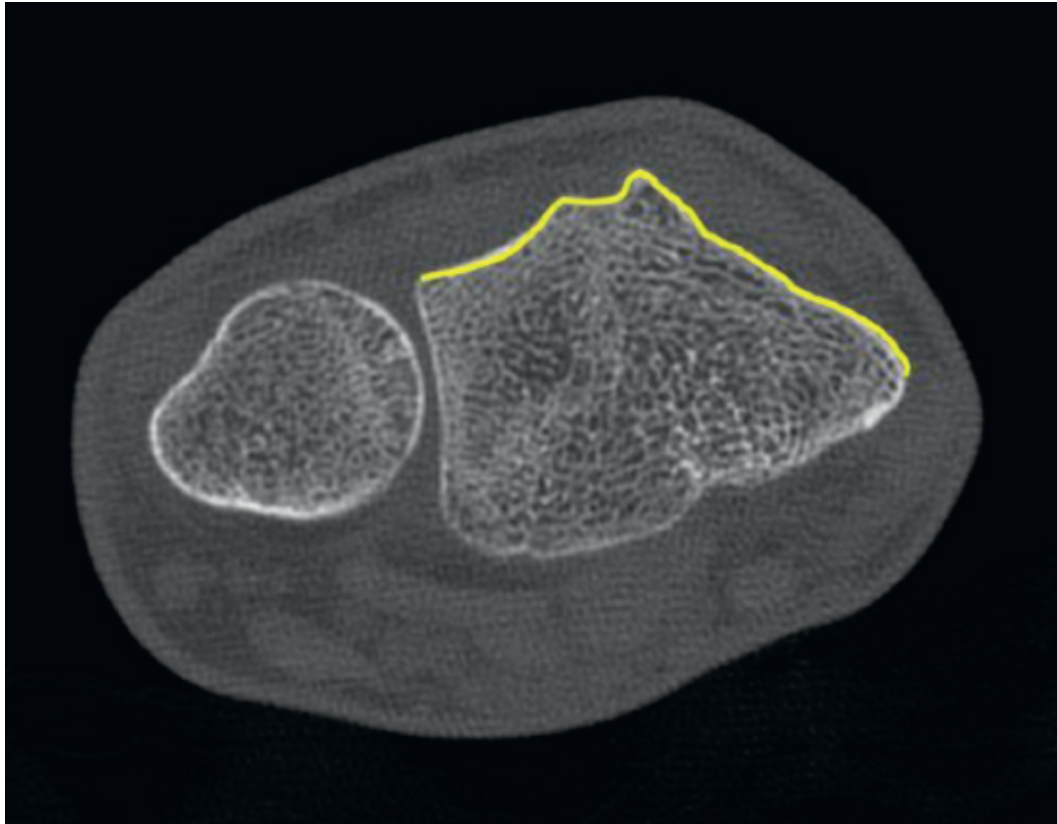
Axial CT image demonstrates the bony undulations of dorsal cortex of the distal radius.
